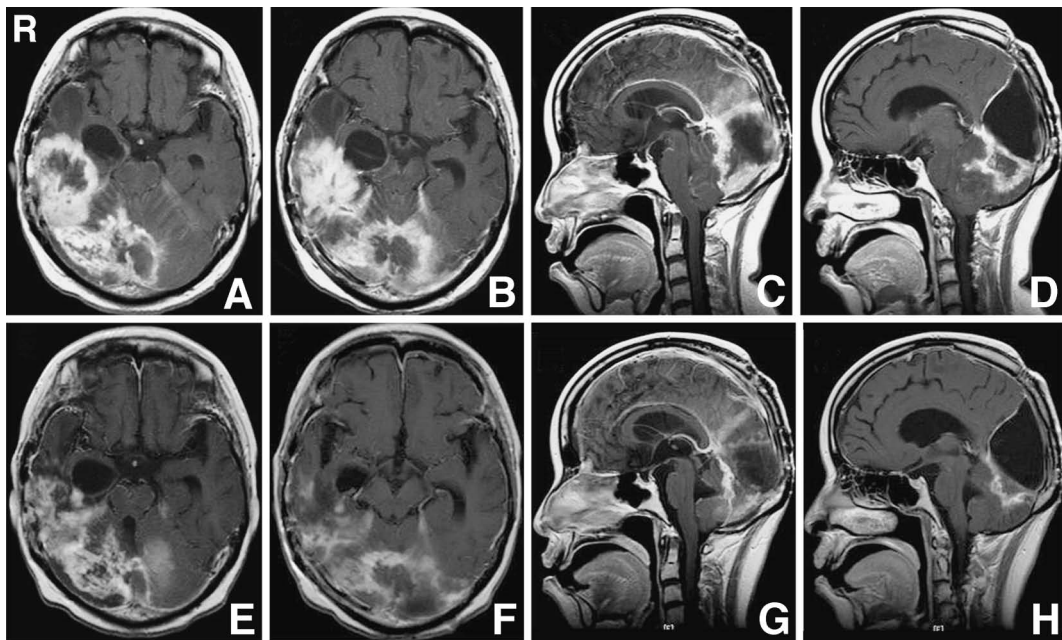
A-D: Axial (A, B) and sagittal (C, D) T₁-weighted magnetic resonance (MR) images with gadolinium before temozolomide (TMZ) therapy showing large tumors in the right temporal lobe and cerebellum, markedly compressing the brain stem. E-H: Axial (E, F) and sagittal (G, H) T₁-weighted MR images with gadolinium after 3 courses of TMZ therapy showing reduced tumor size and improved brain stem compression.
